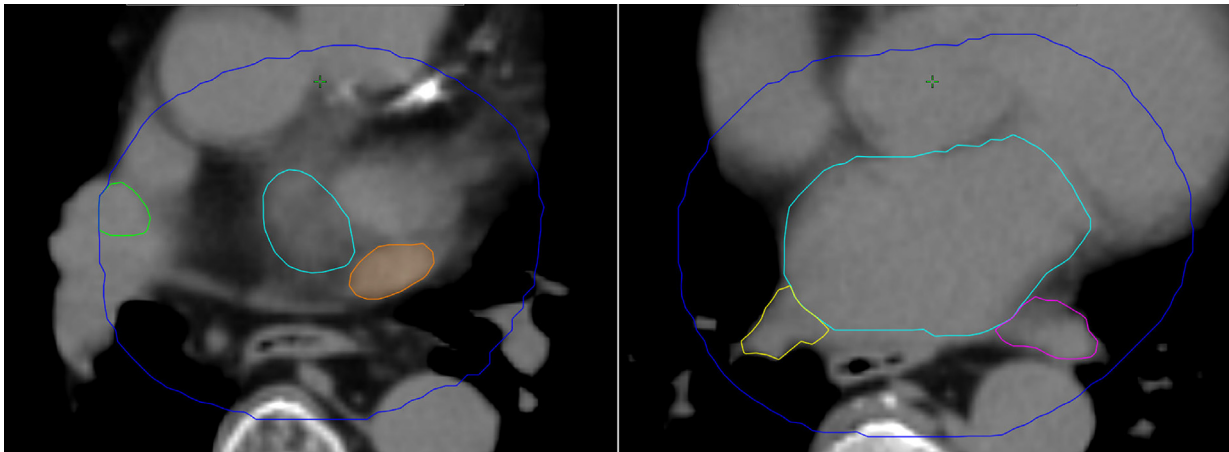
Representative pulmonary vein anatomy of the left atrium (light blue) and the halo (dark blue) on an unenhanced axial CT slice, demonstrating how the right superior pulmonary vein is cropped by the halo peripherally and the right inferior vein is cropped centrally by the LA (green = right superior pulmonary vein; yellow = right inferior pulmonary vein; orange = left superior pulmonary vein; purple = left inferior pulmonary vein).
